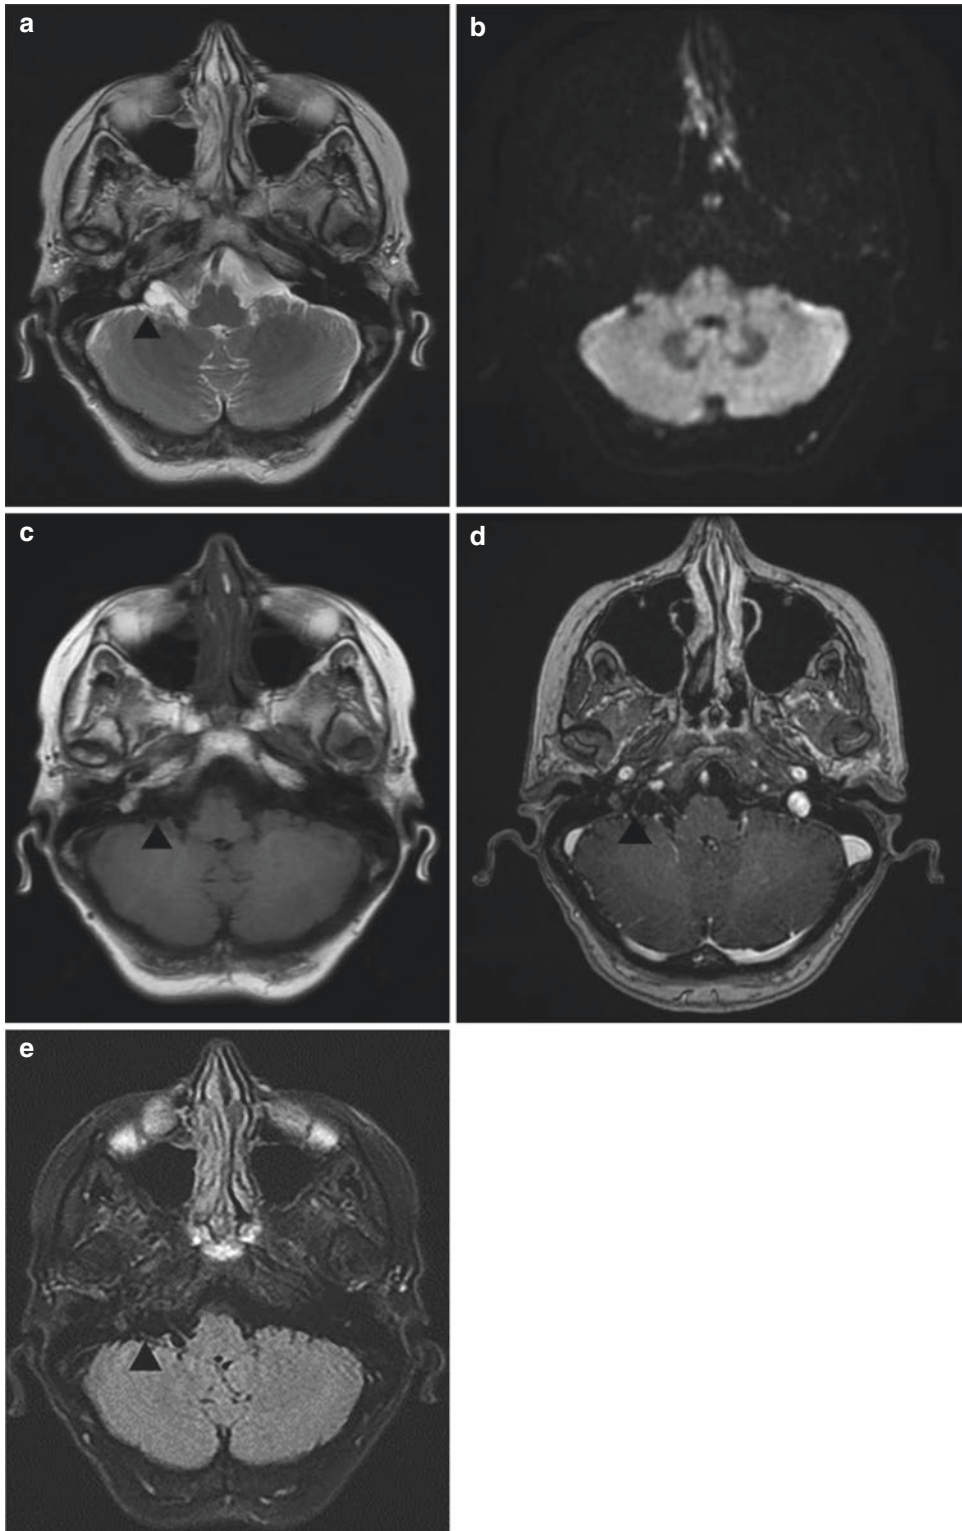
(a–d) A 43-year-old female patient complains of headache. MRI shows no contrast enhancement and no diffusion-restricted extraaxial lesion that can be diagnosed as AC
